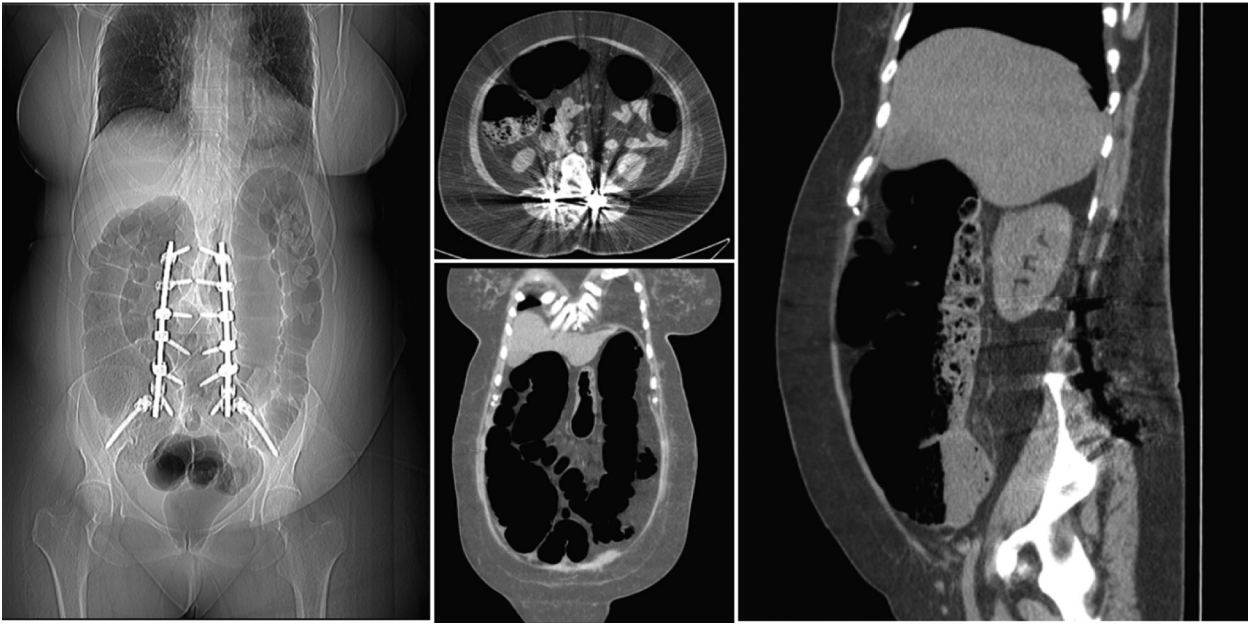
Postoperative radiograph (2nd day) showing dilatation of cecum
